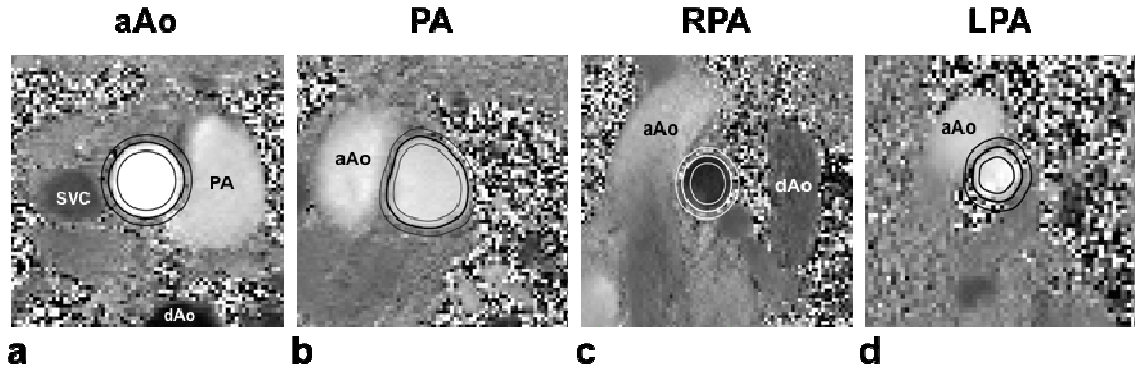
Example PC-MRI phase images and corresponding concentric ROIs in the ascending aorta (aAo), main pulmonary artery (PA), right pulmonary artery (RPA), and left pulmonary artery (LPA) of a single healthy volunteer. Manually contoured ROIs are shown with a thick line and examples of the computationally derived concentric ROIs with ± 2 pixel increments are shown with thin lines. SVC: superior vena cava.
